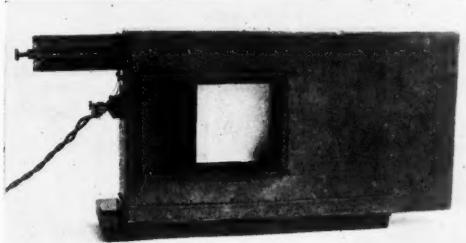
X-ray sensitometer, front view.
